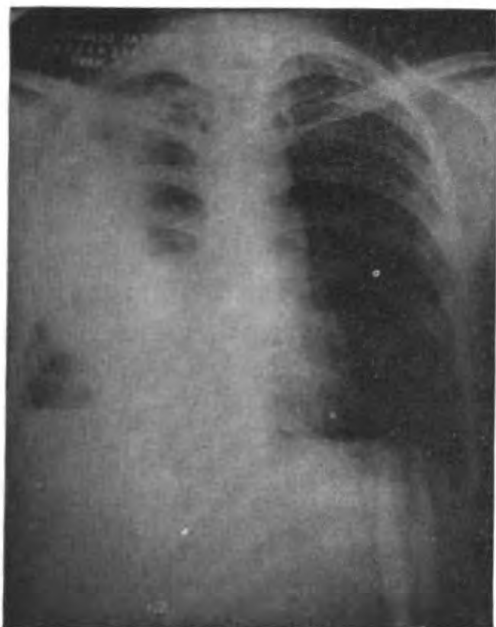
Case 3. Preoperative anteroposterior x-ray showing atelectasis, pleural thickening, hydropneumothorax and multiple fluid levels on the right.
